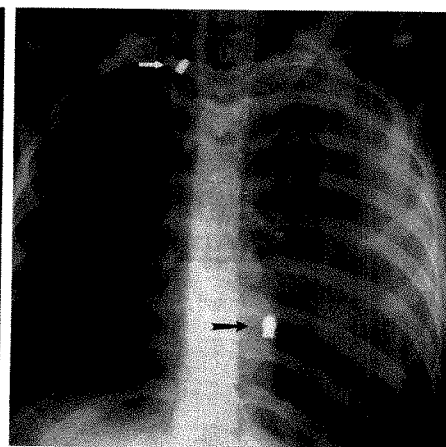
Chest radiograph after handgun injury shows two main foreign bodies: a bullet (small arrow) and metal BB (large arrow), which has been dislodged from bullet tip. Bullet was manufactured with a BB in its tip to promote expansion or mushrooming on impact.
